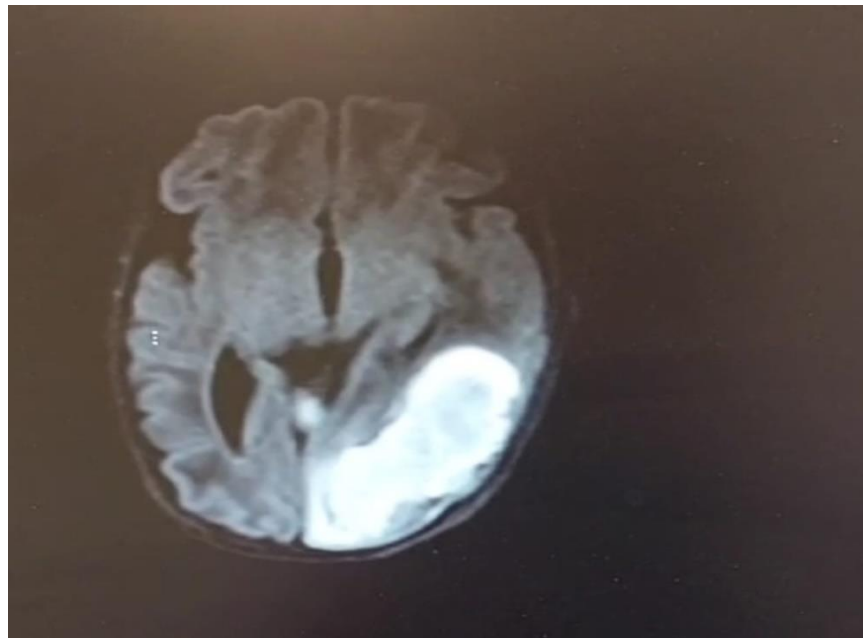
This MRI image provides strong visual evidence of the subacute. The large left parieto-temporo-occipital lesion with mass effect is significant.
